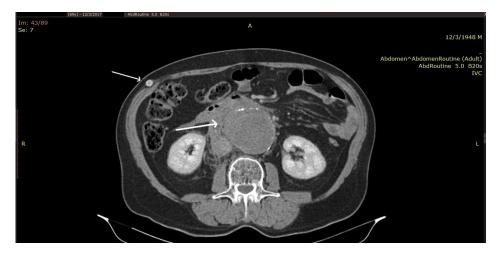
Computed tomography angiography (CTA) showing a rupture of the aneurysmal sac (*thick arrow*) and the patent axillobifemoral bypass (*thin arrow*).
